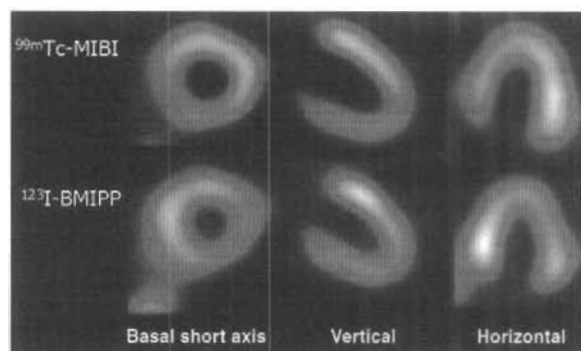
^{99m}Tc -sestamibi (^{99m}Tc -MIBI) (upper panel) and beta-methyl-p- ^{123}I -iodophenyl-pentadecanoic acid (^{123}I -BMIPP) (lower panel) single-photon emission computed tomography images showing decreased ^{99m}Tc -MIBI uptake in the inferoseptal segments and increased ^{123}I -BMIPP uptake in the inferoseptal and septal segments (^{99m}Tc -MIBI/ ^{123}I -BMIPP mismatch)
